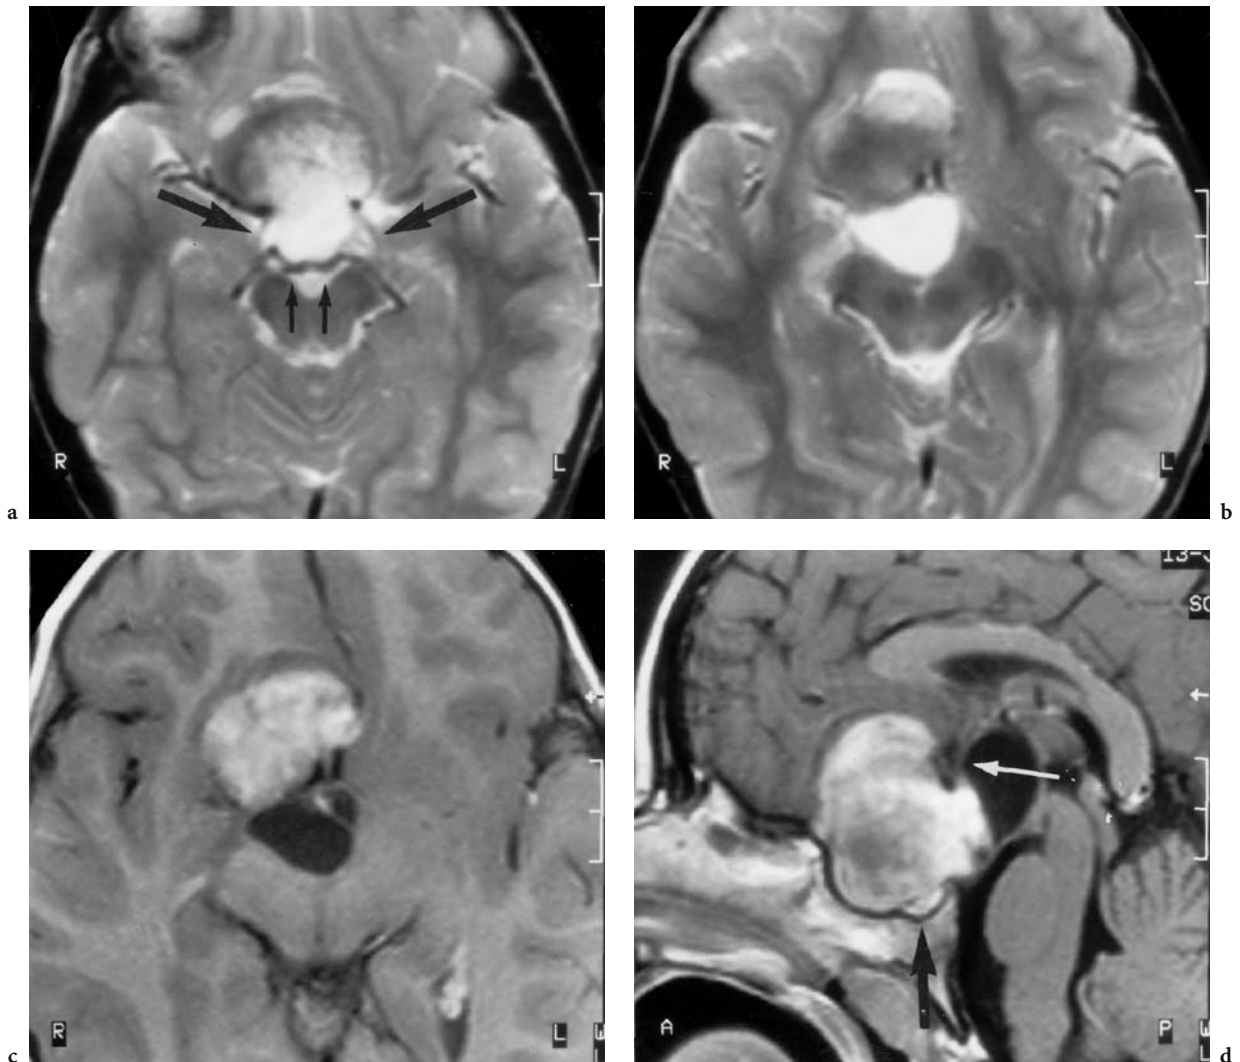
A 3-year-old boy with a visual deficit on the right side and initial right optic nerve atrophy (on ophthalmoscopy). Diagnosis: glioma (astrocytoma) of the optic chiasm. MRI: a Axial T2-weighted view at the level of the chiasm, demonstrating a dumbbell-shaped tumor with a predominantly high signal intensity, extending to the suprasellar cistern and expanding the vessels of Willis' circle and both optic tracts (*arrows*). Note the impression of both mammillary bodies (*small arrows*). b The next slice shows an additional dorsal tumor cyst. Note the absence of perifocal edema. c Corresponding T1-weighted, contrast-enhanced view, showing enhancement of the solid tumor part. d Midsagittal, T1-weighted, contrast-enhanced view demonstrating the cystic tumor region posterior and the solid tumor region anterior to the pituitary stalk (*white arrow*). Note substantial enlargement of the sellar configuration, but an intact diaphragm, and normal pituitary gland (*black arrow*)
